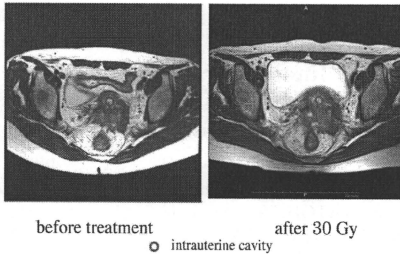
MRI images before treatment and after 30 Gy.
